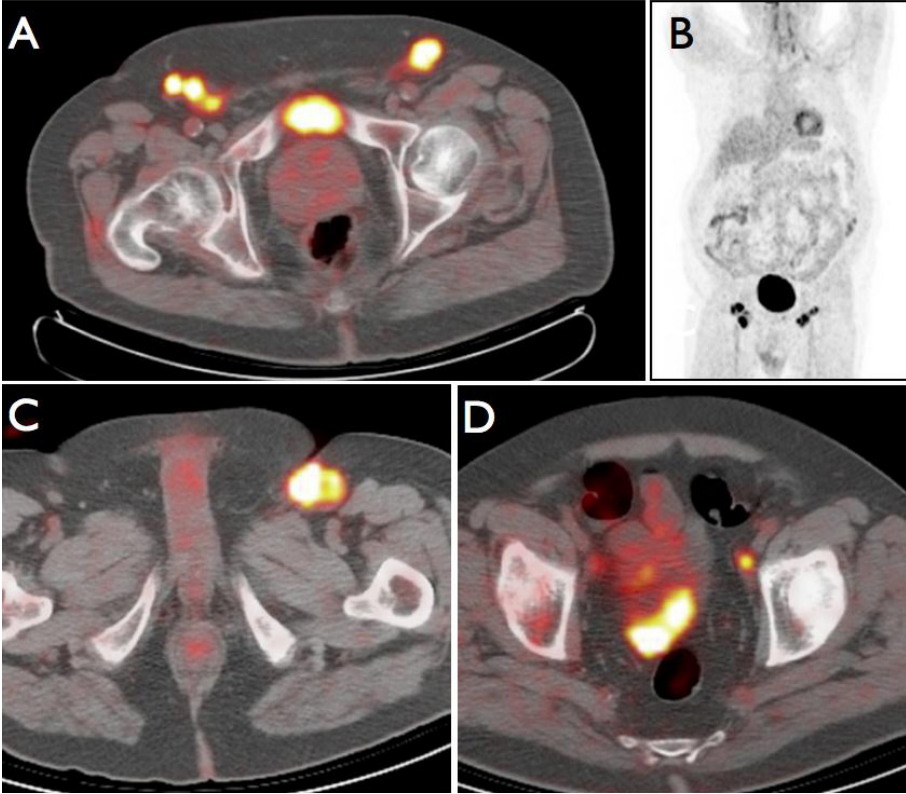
PET/CT images showing  $[^{18}\text{F}]\text{FDG}$  avid LN metastases in both groins (A), but not in other regions (B). In another patient with  $[^{18}\text{F}]\text{FDG}$  avid LN metastases in the left groin (C), a left iliac LN metastasis is also seen (D).
